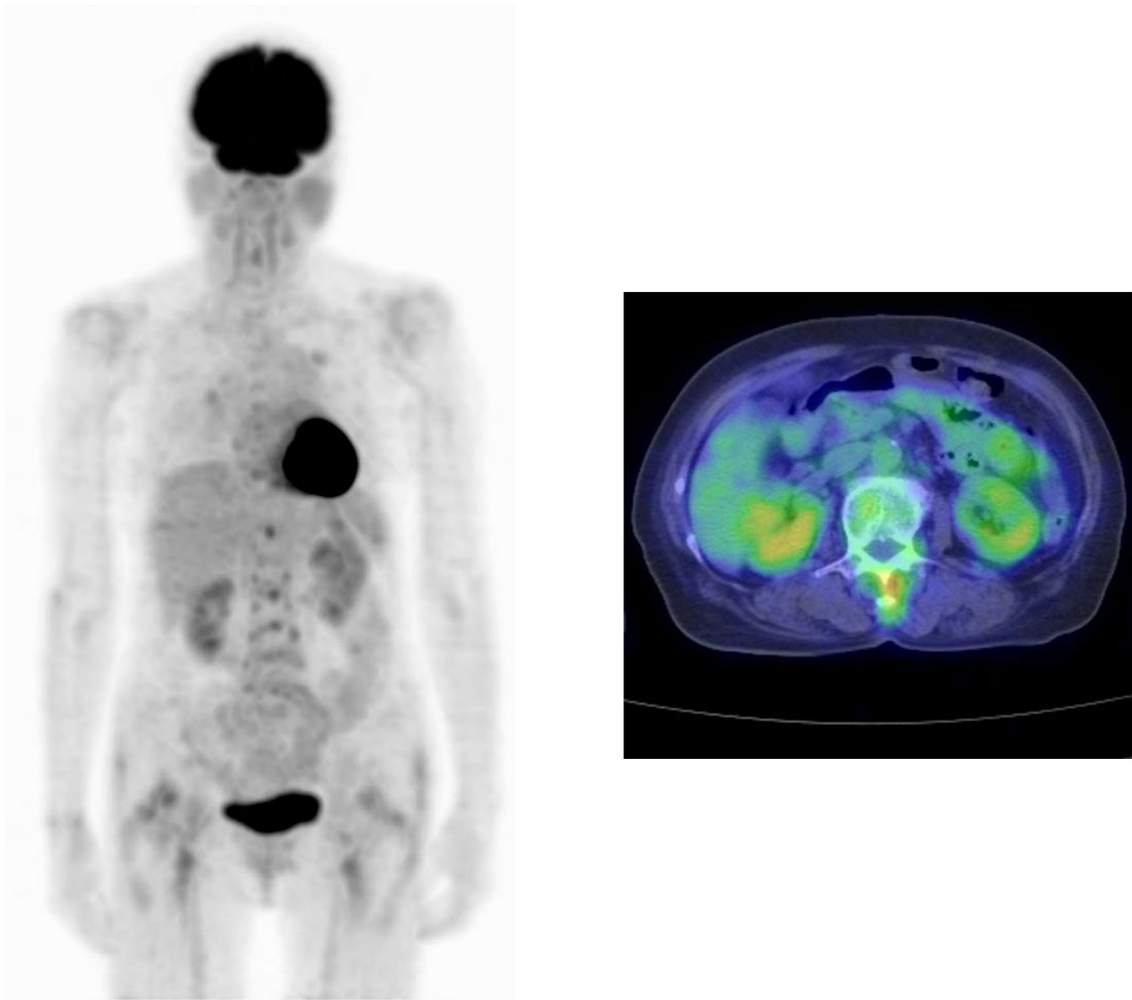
^{18}F -FDG PET/CT images of an 81-year-old female with suspected Baastrup disease. There is linear FDG uptake along the interspinous ligament
